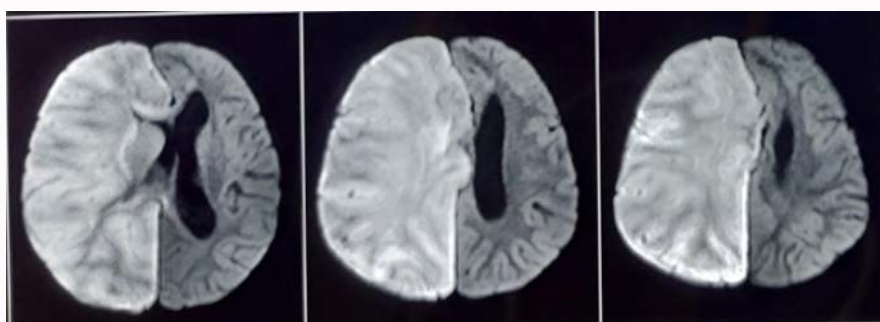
MRI BRAIN, showed edematous right cerebral cortex, subcortical and deep white matter along with mass effect and dilatation of contralateral lateral ventricle.
